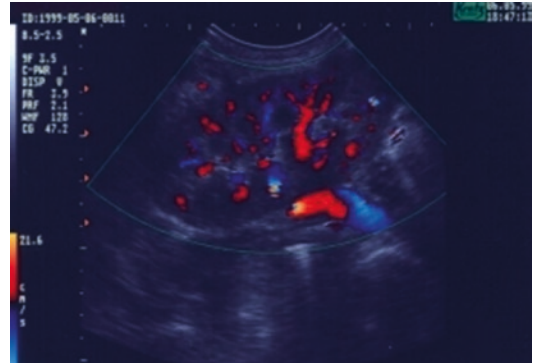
Echocolor Doppler of a transplanted kidney
